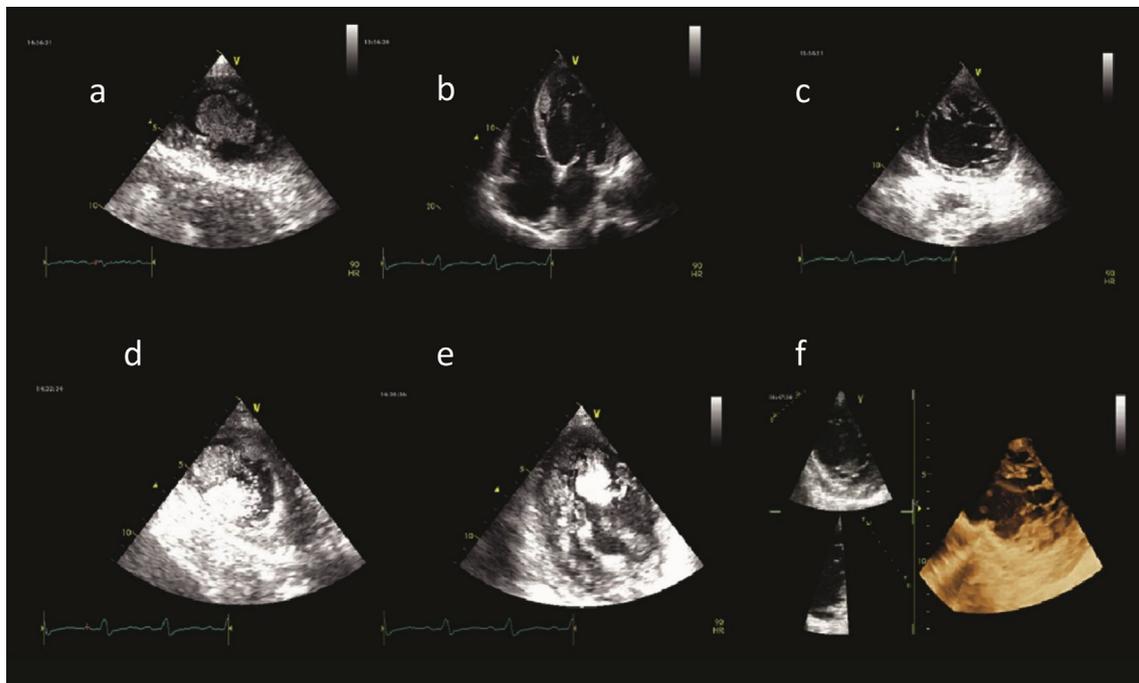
a, b). Urgent transthoracic echocardiography (TTE) revealed a dilated left ventricle, severely reduced ejection fraction (LVEF = 20–25%), two large thrombi and near normal right cavities. c). The whole LV picture was typical of NCC. d–f). Further study with contrast and 3D demonstrated clearly the abnormal trabeculations and the two large thrombi in the LV (one was attached to the apex and the other one was entrapped in the trabeculations of the intraventricular septum).
